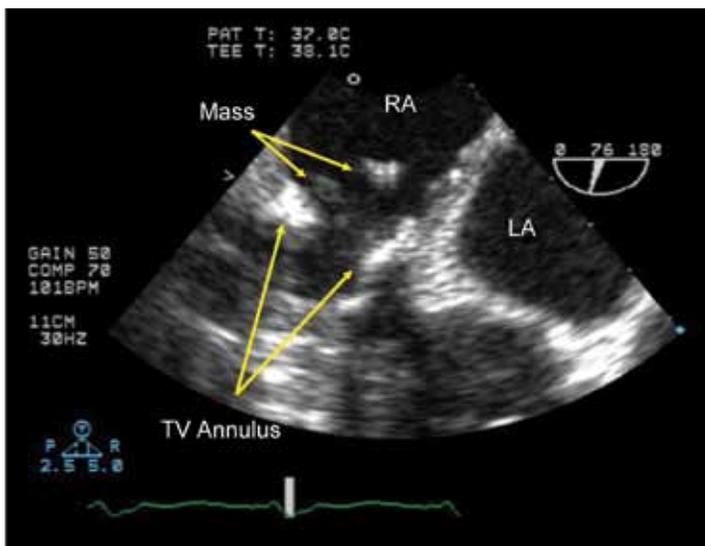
Transesophageal echocardiogram showing the mass seen on and around the tricuspid valve (TV) annulus. RA=right atrium, LA=left atrium.
